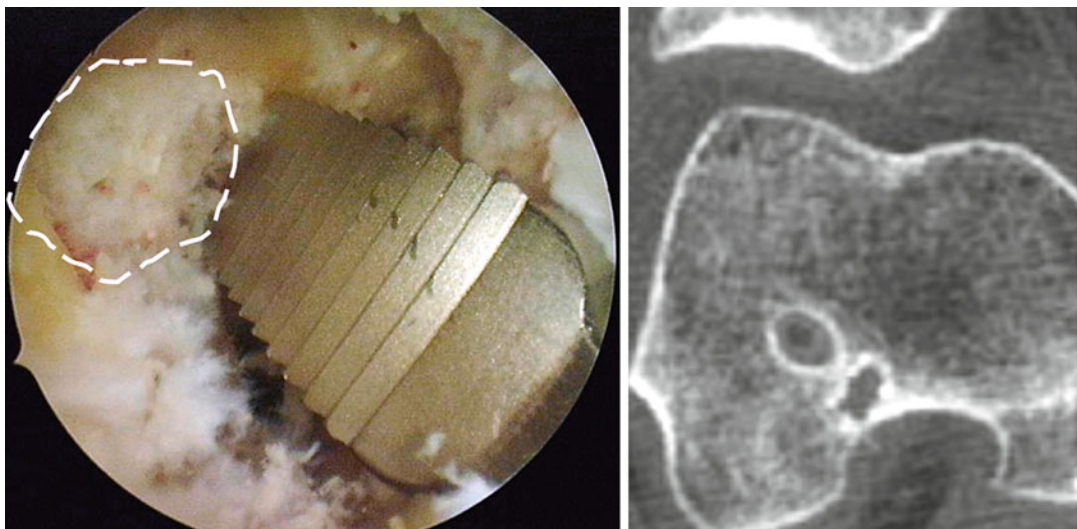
A rasp correspondent to the dimensions of the graft is used to place a new anatomical tunnel. On CT the tunnel position is documented. A conventional round
